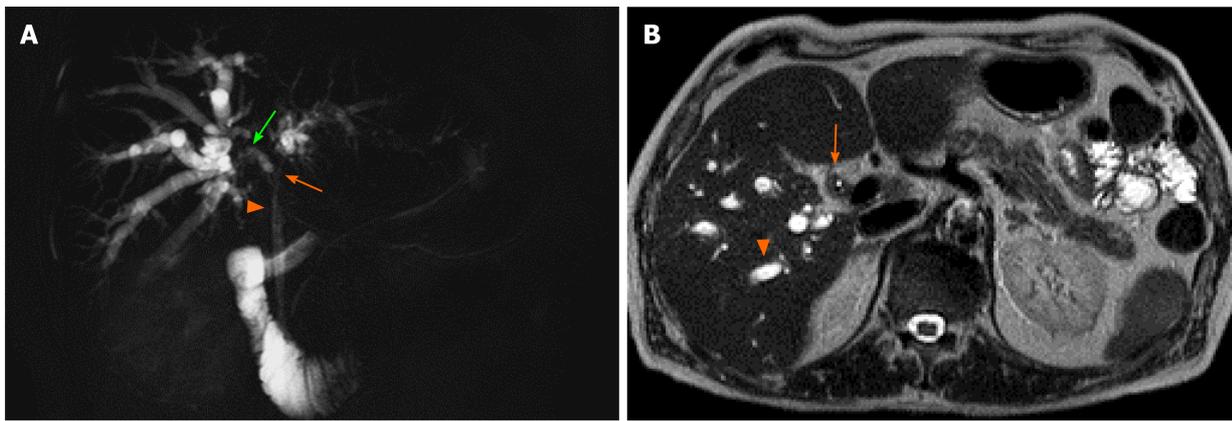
Patient was a 67-year-old man who was admitted to our hospital due to obstructive jaundice. A: Cholangio-MRI showed severe and long stricture of the common (arrowhead) and both right (green arrow) and left (orange arrow) hepatic ducts and, to a lesser extent, of distal branching of both right anterior and posterior segmental duct, with secondary upstream intrahepatic bile duct dilatation; B: Axial T2-weighted magnetic resonance image showed intrahepatic biliary dilatation (arrowhead) due to a T2 isointense intraductal mass (arrow). Preoperative imaging was consistent with an extrahepatic cholangiocarcinoma of Bismuth-Corlette type IV. Endoscopic preoperative biliary drainage was performed to relieve the obstruction. After multidisciplinary discussion, extended right hepatectomy was planned. Portal vein embolization of the right liver was carried out three weeks before the operation. Then, the patient underwent right hepatectomy extended to segment I, complete extirpation of the extrahepatic biliary system, and simultaneous pancreatoduodenectomy due to tumour involvement of the distal common bile duct at intraoperative frozen section. Thus, hepatopancreatoduodenectomy was the final surgical procedure. Final pathology showed a moderately differentiated cholangiocarcinoma with mucinous component, with 14 negative lymph nodes. Postoperative course was complicated by development of transient liver failure with ascites, electrolyte imbalance, and delayed gastric emptying with nausea and vomiting. The patient was discharged in postoperative day 58 and did not undergo chemotherapy. After 12 months, the patient is doing well, in stable health condition.
